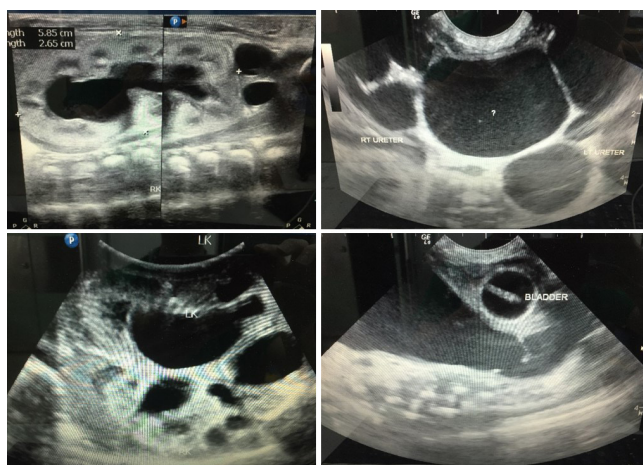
Ultrasonography 1 day after birth revealed bilateral UVJO.
